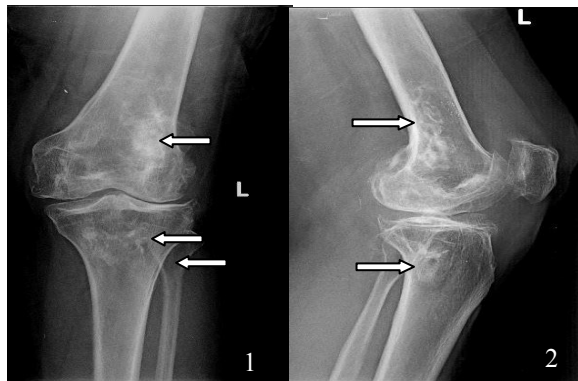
Radiograph AP and lateral view of knee showing multiple ill-defined metaphyseal lesions in the medullary region of femur and tibia with central lucency and surrounded by sclerosis with a serpiginous border.
